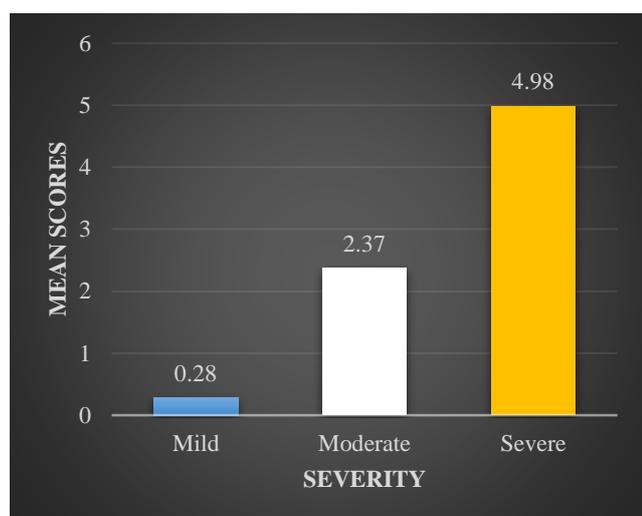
Chest X-ray scoring with respect to severity of COVID pneumonia.
